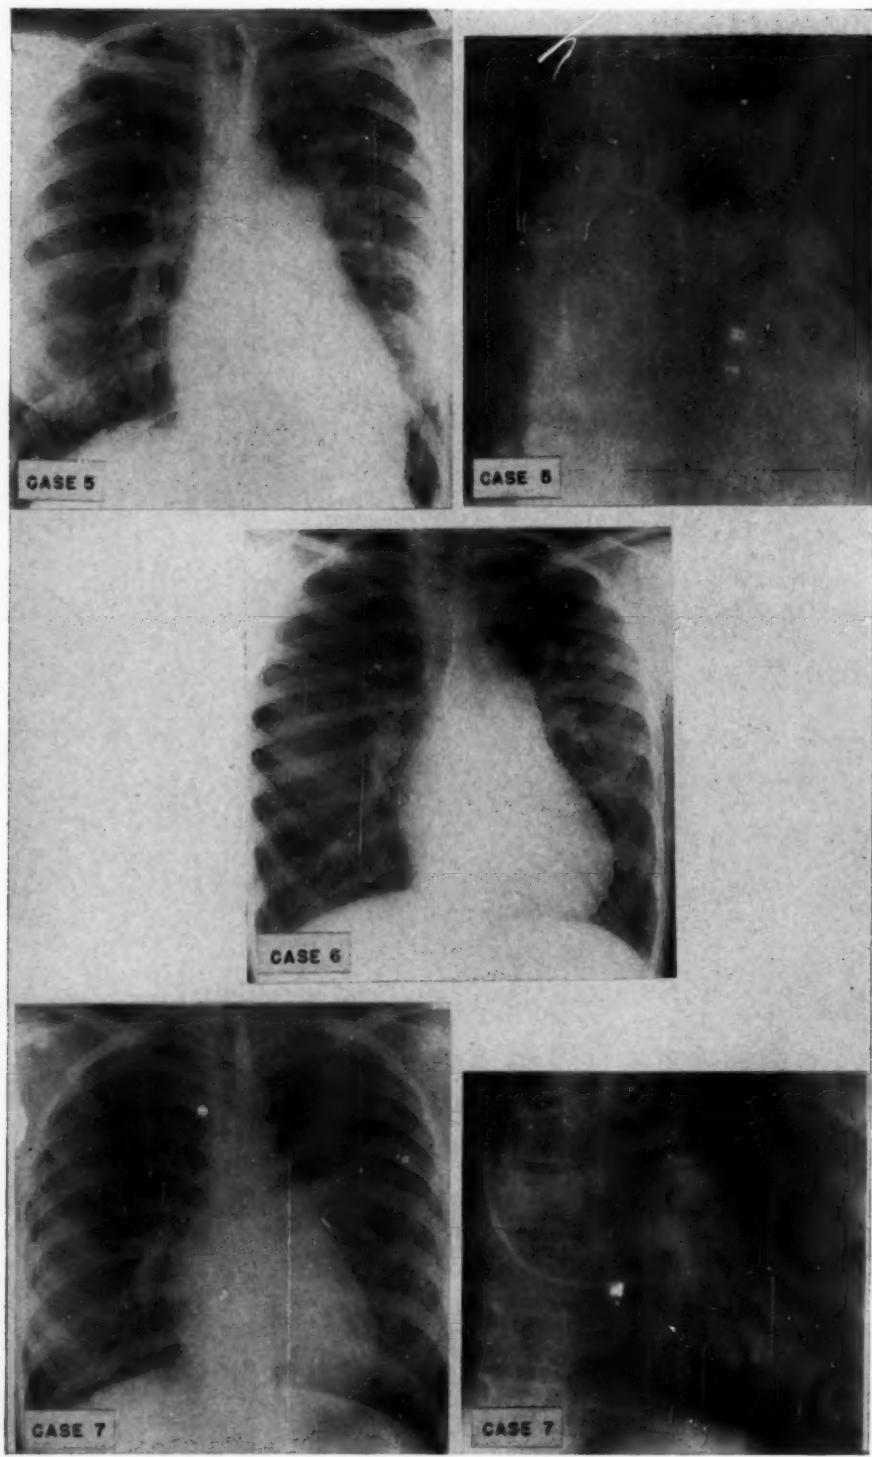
Chest x-rays in three cases of pulmonic stenosis with interatrial septal defect. Films taken at cardiac catheterization in Cases 5 and 7 show catheter in left atrium.
